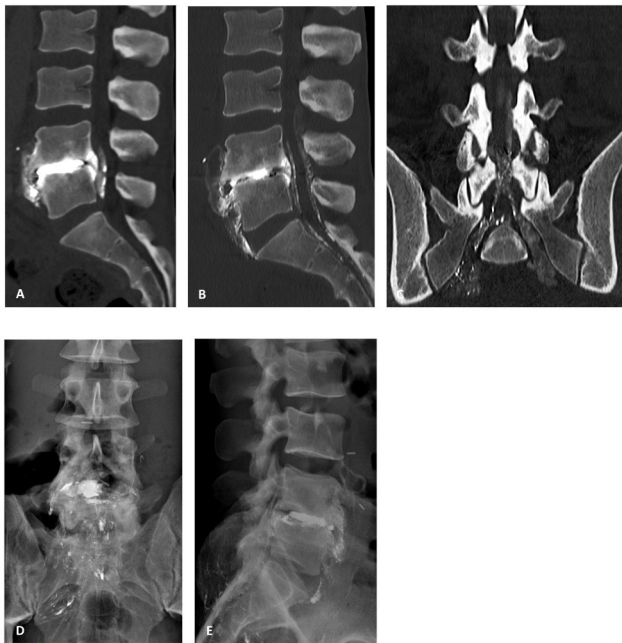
Lumbar CT scan and lumbar X-ray of the patient revealing a disintegration of the hyperdense material along the epidural space and right nerve S1. (A) First lumbar CT scan, sagittal section with hyperdense material in L4/L5 intervertebral disc with minimal posterior flow. (B) Second lumbar CT scan, 2 weeks after the first CT scan, sagittal section with hyperdense material with flow in the anterior and posterior epidural space. (C) Second lumbar CT scan, 2 weeks after the first CT scan, coronal section with hyperdense material with in the epidural space and among nerve roots. (D) Face X-ray, 2 weeks after the first CT scan, hyperdense material with in the epidural space and among nerve roots. (E) Profile X-ray, 2 weeks after the first CT scan, posterior migration of the hyperdense material through the sacral foramina into the paraspinal soft tissue, and into the anterior paravertebral space.
